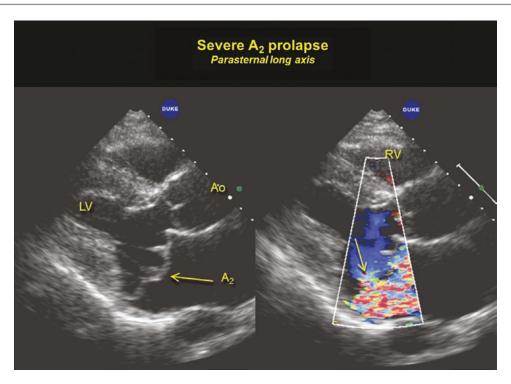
Parasternal long axis of the mitral valve in a patient with huge A_2 segment prolapse (arrow left panel). The mitral regurgitation is directed posteriorly (arrow, right panel)
